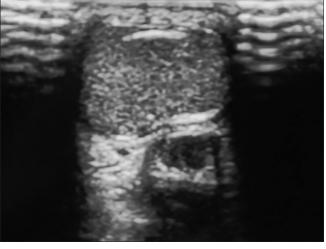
Grayscale ultrasound of a lesion in the nape of the neck with a total score 0 and USG diagnosis of benign lesion which was confirmed on HPE (epidermal inclusion cyst)
